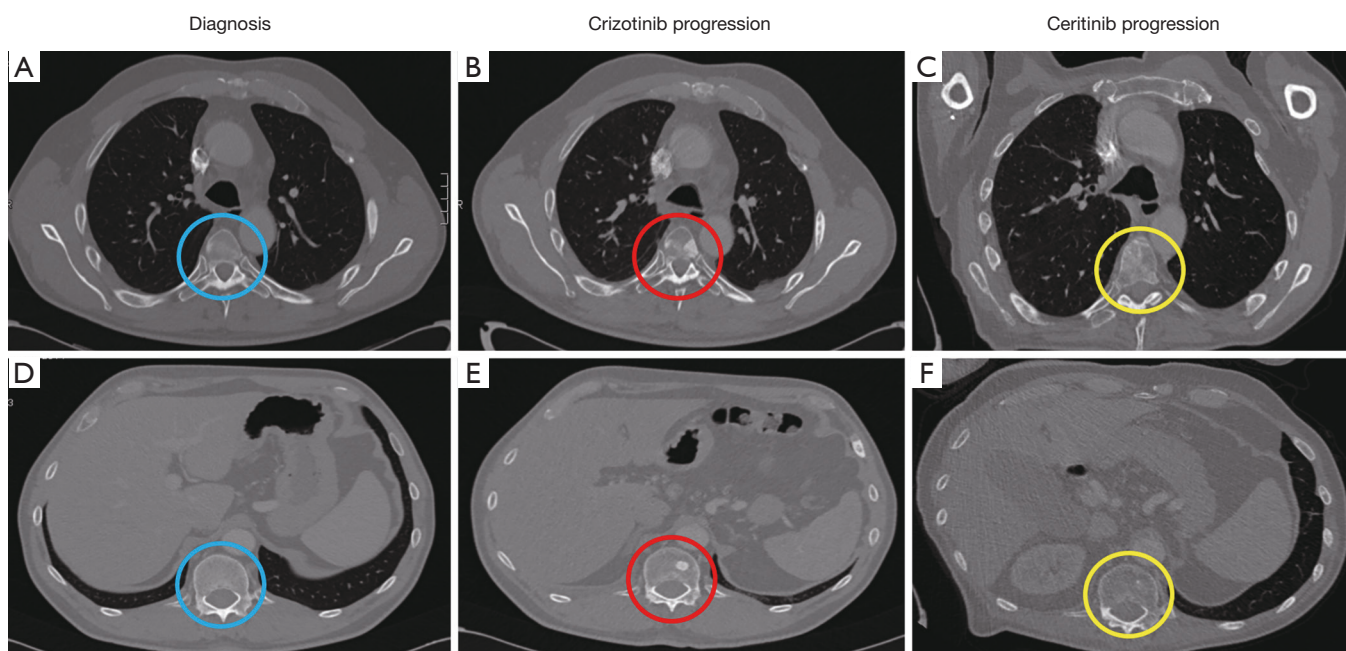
CT scans at times of diagnosis and progression during crizotinib and ceritinib treatment. (A) CT scan at time of diagnosis; (B) CT scan showing new T4 vertebral metastasis upon crizotinib progression; (C) The CT scan reveals a partial remission of T4 vertebral lesion with ceritinib treatment; (D) CT scan at time of diagnosis; (E) CT scan showing new T10 vertebral metastasis upon crizotinib progression; (F) The CT scan reveals a partial remission of T10 vertebral lesion with ceritinib treatment.
